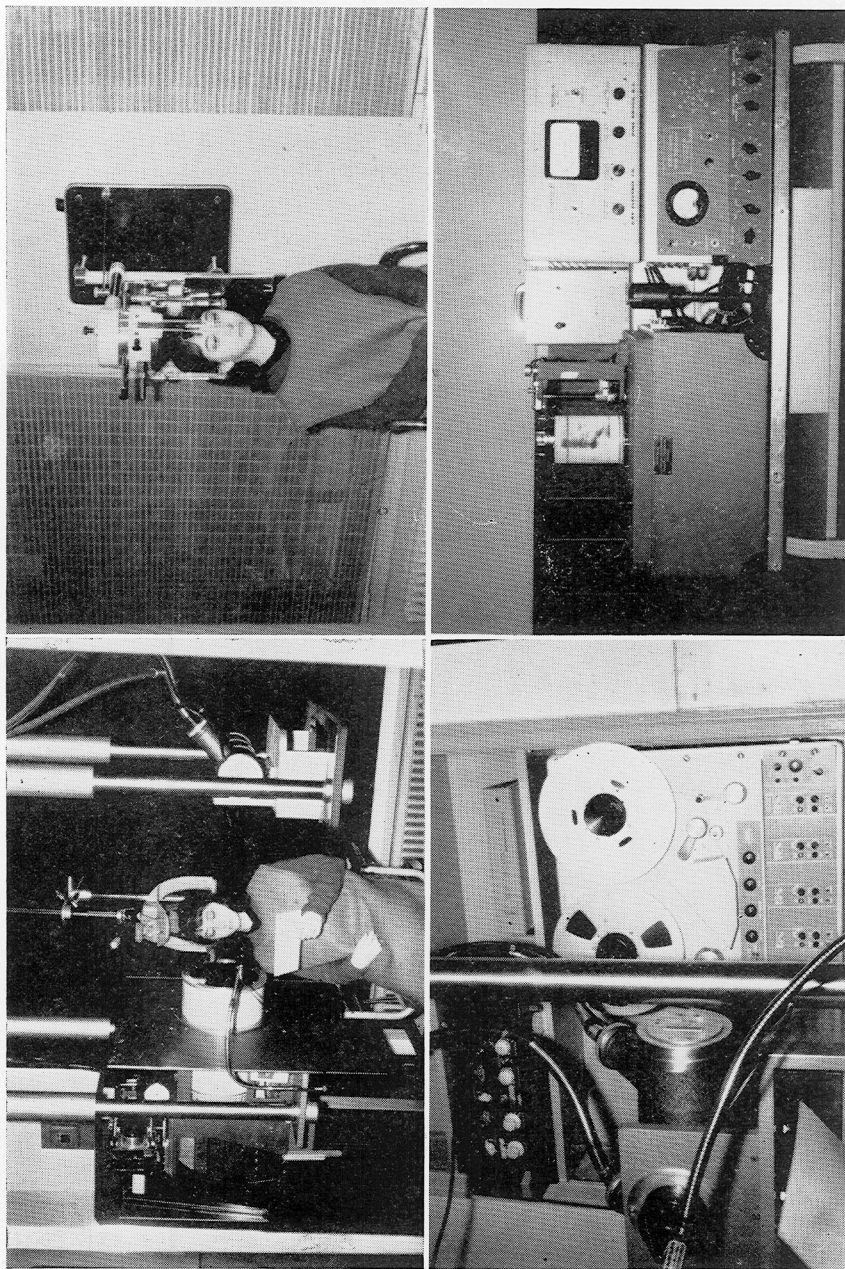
Upper left: cineradiographic system. Upper right: roentgenographic cephalometer. Lower left Ampex SP-30 4-channel tape recorder synchronized with cineradiographic unit. Lower right: sound spectographic with scale magnifier and amplitude display.
